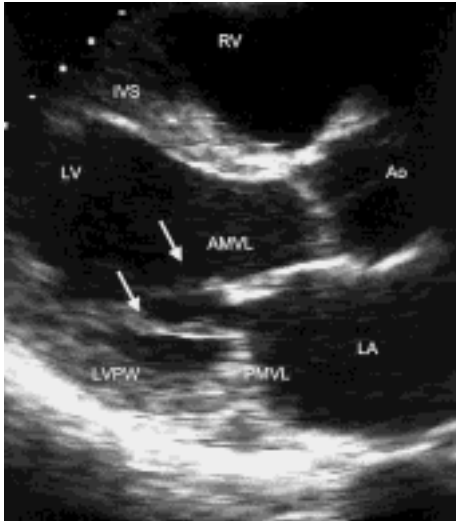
Parasternal long-axis view. Arrows show chordae.
